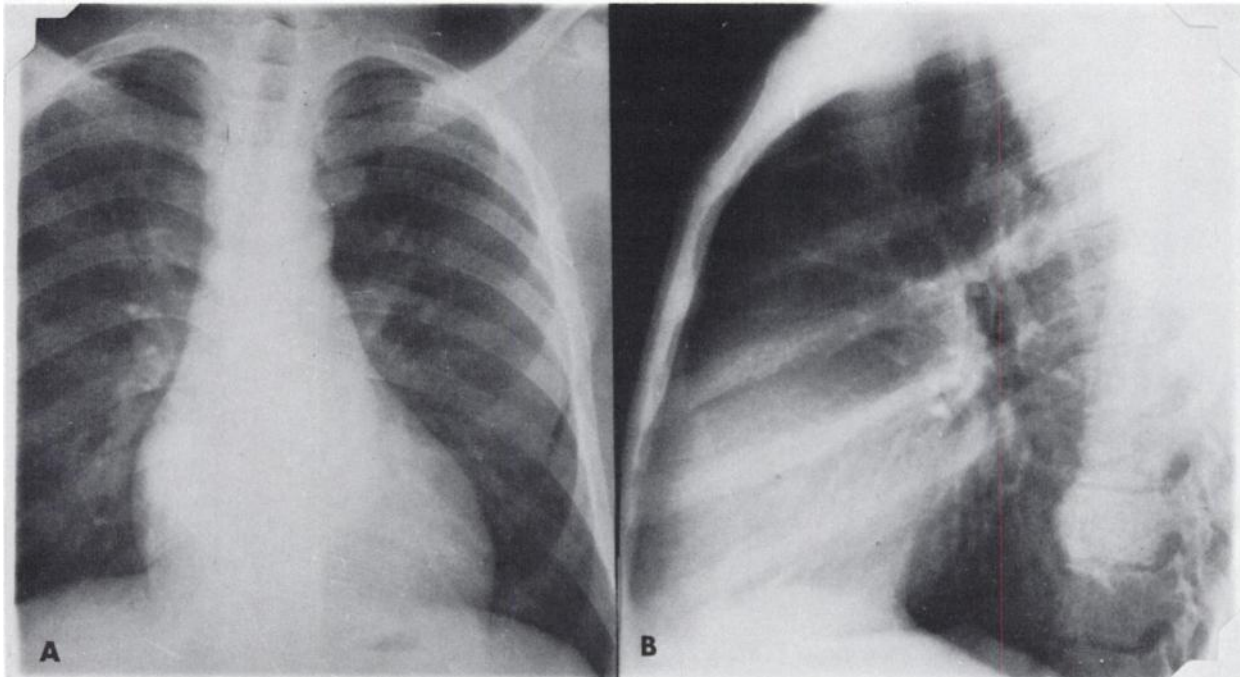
PA (A) and lateral (B) chest roentgenograms record multilobular mediastinal masses visible through the heart shadow and overlying the spine on lateral view.
